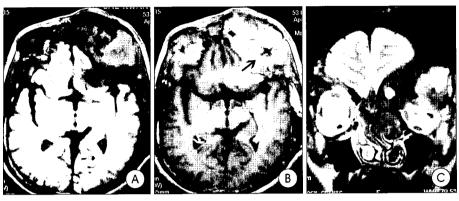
T1—weighted axial magnetic resonance(MR) image of brain(A), T1—weighted axial enhanced MR image(B) and T1—weighted coronal MR image(C) show the well demarcated, slightly enhanced heterogenous mass lesion inside the fibrous dysplastic bone which was present before. The mass is compressing the left eye ball from its lateral side(arrow).
